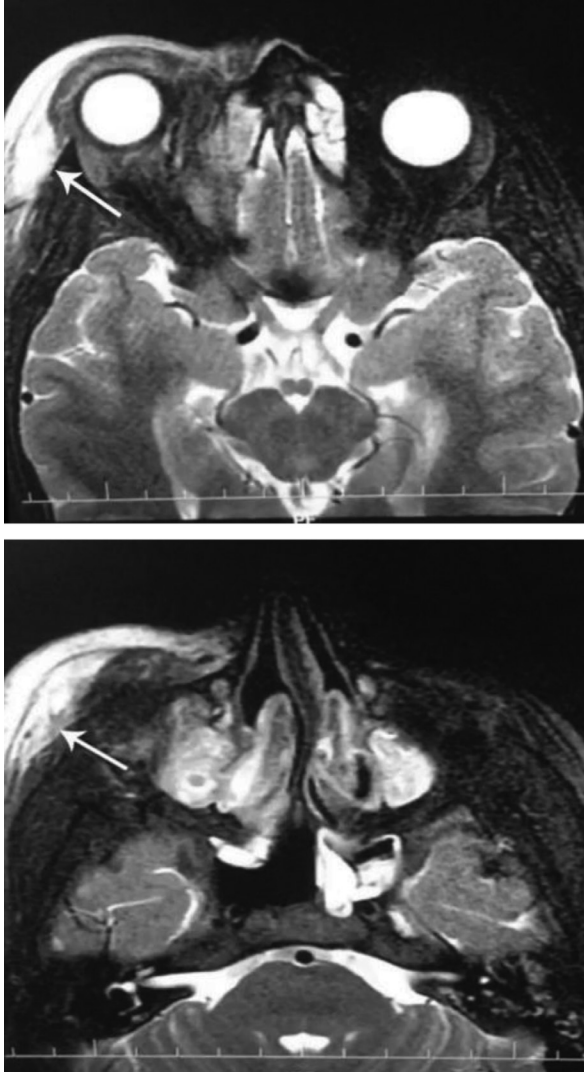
11-year-old girl. Orbital magnetic resonance image of a patient with orbital cellulitis. A subperiosteal abscess of 28x9 mm dimensions is noted at the lateral extra-corneal area, which indented the lateral rectus muscle
